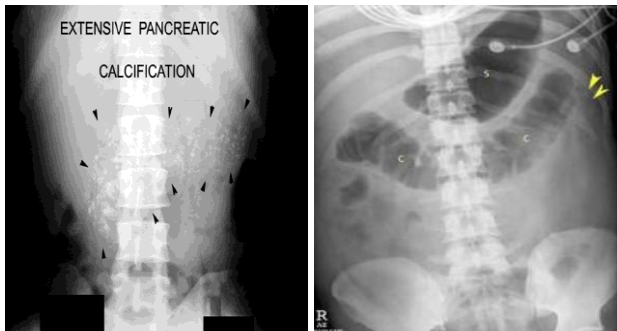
Plain radiograph of erect Abdomen - chronic pancreatitis
